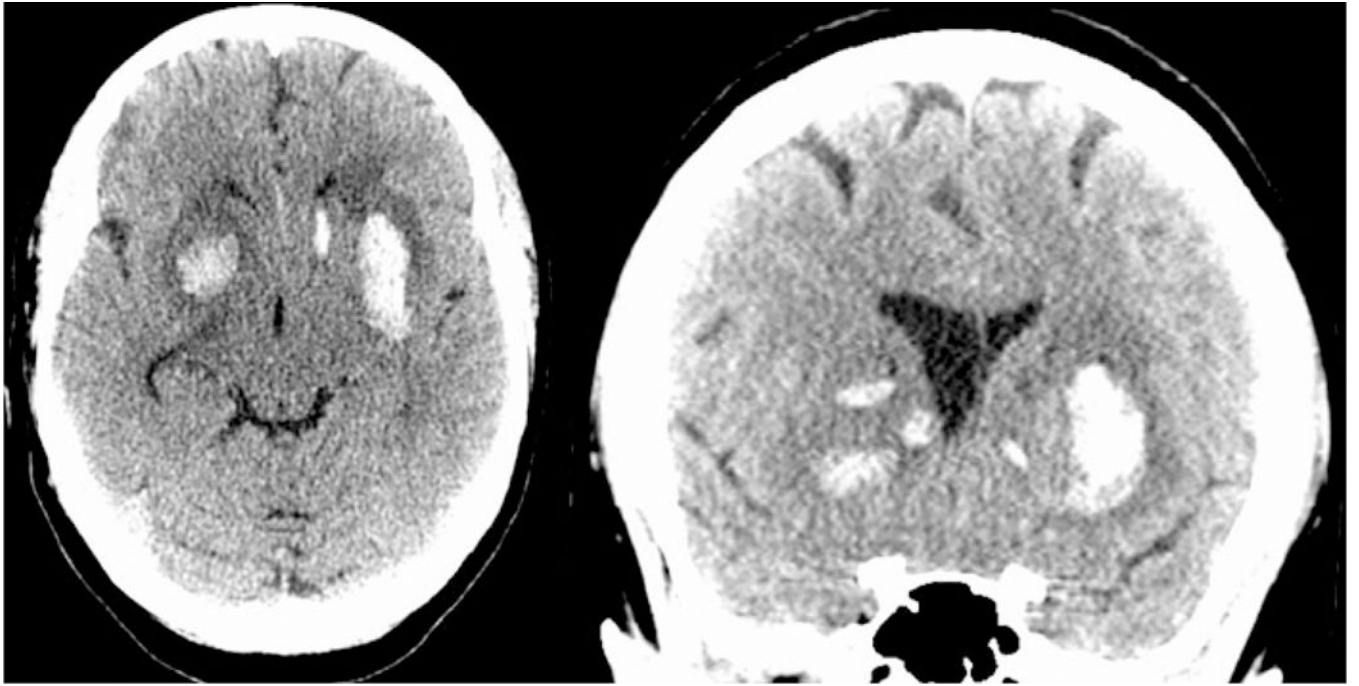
Head CT on initial presentation (day 1), axial section and coronal reformat, showing bilateral basal ganglia hemorrhages.
